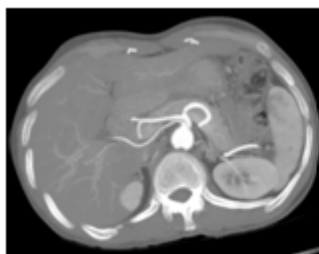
Contrast enhanced CT of the abdomen arterial phase MIP image (axial view) showing absent common hepatic artery and direct origin of right hepatic artery from aorta. The left hepatic branch, left gastric and splenic artery have a common origin
